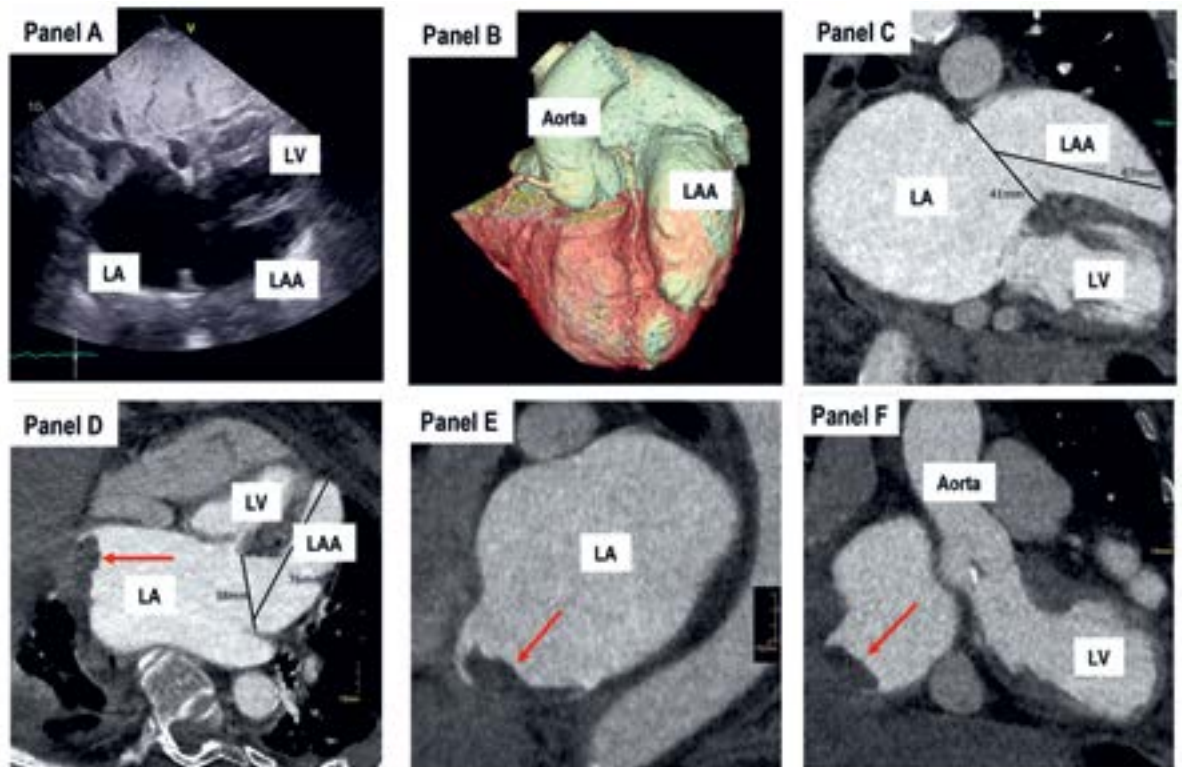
Panel A: Echocardiographic subcostal view showing the left ventricle (LV), the left atrium (LA) and the aneurysmatic left atrial appendage (LAA). Panel B: 3D reconstruction of the heart showing the LAA aneurysm. Panel C: Two-chamber view showing the size of the LAA aneurysm in comparison to the LV. Panels D to F: Modified axial, short axis and three chamber views showing the thrombus in the left atrium (red arrow).
